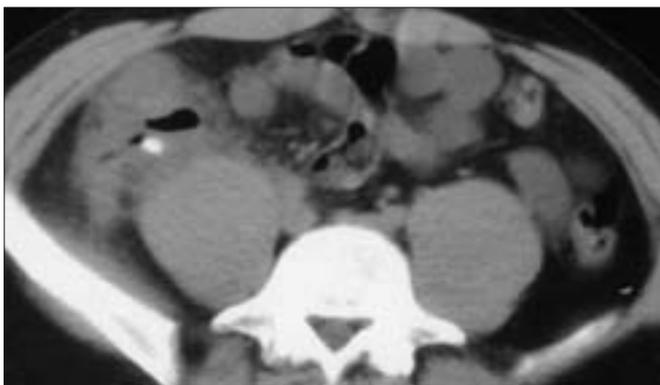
Unenhanced CT image demonstrating an appendicolith and an inflammatory process surrounding the appendiceal lumen.
